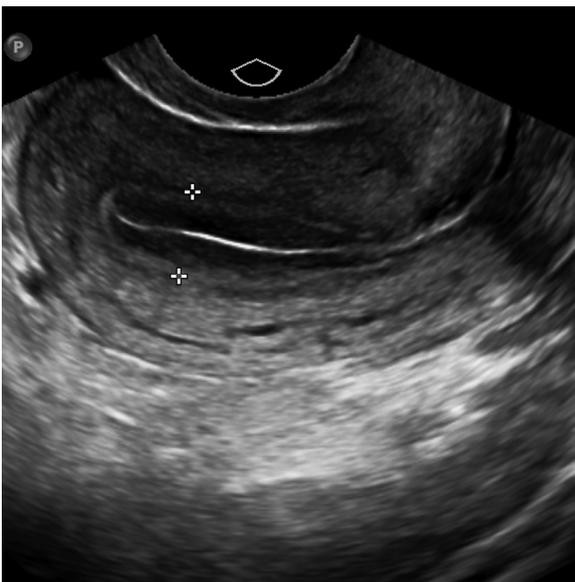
A 19-year-old female with normal endometrium in periovulatory phase. Transvaginal sagittal ultrasound shows endometrium measures 9 mm (calipers; typically 4–8 mm in the first half of the menstrual cycle). There is a trilaminar appearance. Central functional layer of endometrium is relatively hypoechoic.
